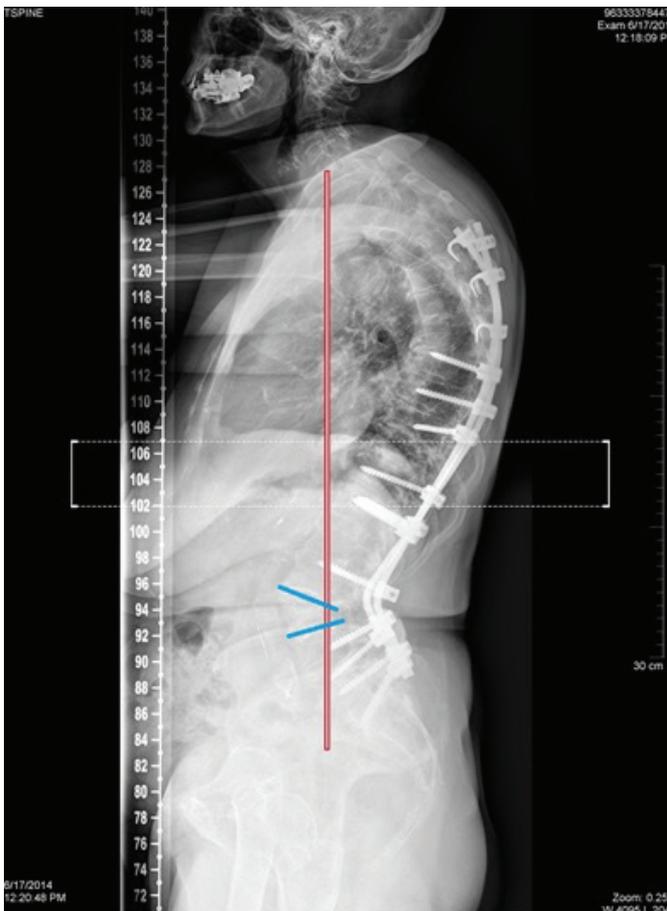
Postoperative lateral standing view X-Ray.
